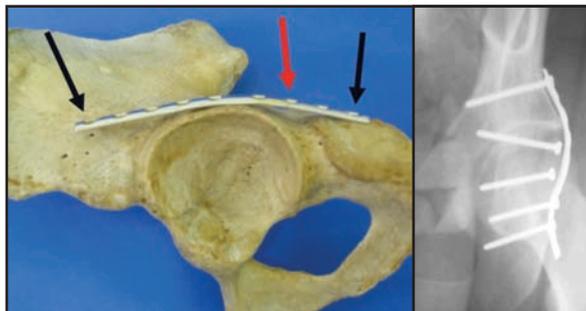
Black arrows showing screw fixation points and red arrow showing the position of the sub-cotyloid fossa screw that will tension the plate with the end result shown on the X-ray on the right
